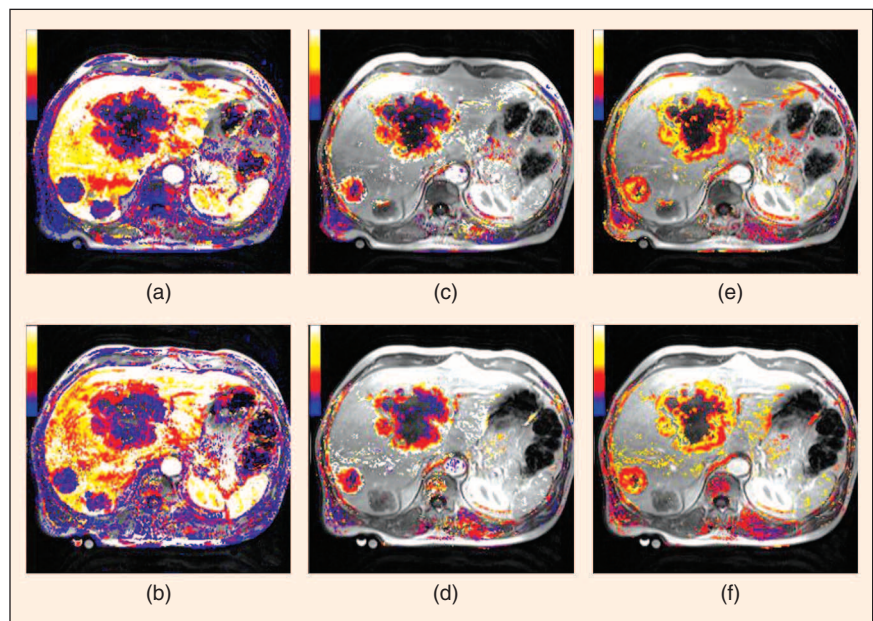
Quantitative and semiquantitative images showing reproducibility of liver DCE-MRI. Semiquantitative mean gradient ((a), (b)) and quantitative ((c), (d): K^{trans} maps, scale 0–1 min^{-1} and (e), (f): v_e maps, scale 1–100%) calculated images for the same patient as in Figure 12 on two consecutive days. The mean gradient image shows that liver enhancement is greater than the tumors in this patient. No color is seen in normal liver on the K^{trans} map because of modeling failures related to hyper-vascularity/dual blood supply. Modeling failures due to high vascular volume also account for lack of color in the kidney. The follow-up images on subsequent days showed excellent slice reproducibility.
